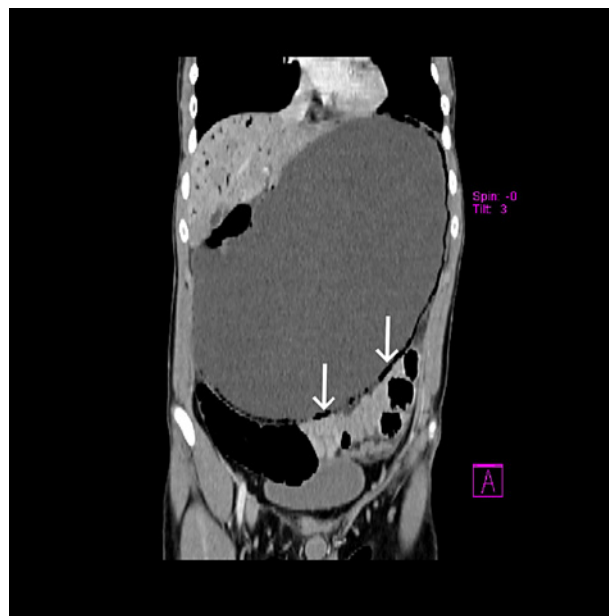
Coronal plane CT reconstruction: gastric dilatation is seen along with pneumatosis (arrows).
